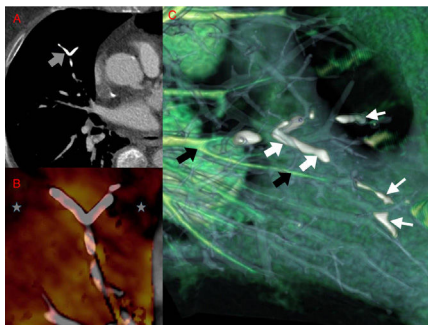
Dual-energy computed tomography after the administration of intravenous iodinated contrast medium. (A) Axial image revealing a high-density branched linear image in a subsegmentary artery in the medial segment of the middle lobe (gray arrow) suggestive of cement embolism. (B) Iodine perfusion map revealing areas of hypoperfusion (gray stars) distal to the dense linear lesion described previously. (C) Vascular map showing vessels containing iodine colored green (black arrows) and filling defects attributable to the cement in white (thick white arrows). Note how this kind of reconstruction can be used to identify a greater number of small caliber vessel defects (thin white arrows).
